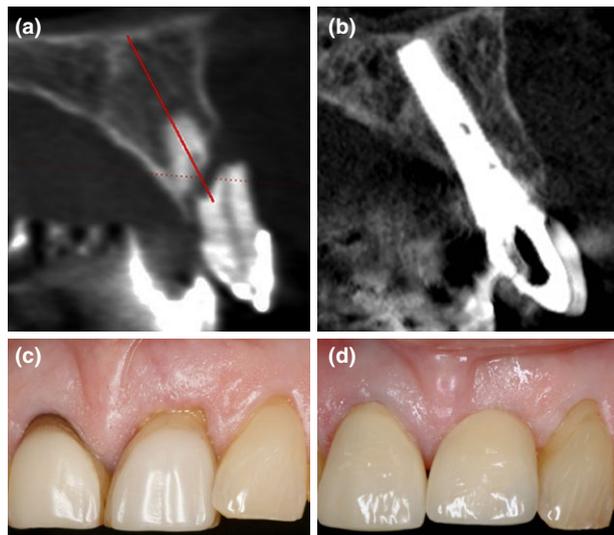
Immediate implant insertion, immediate reconstruction, and immediate provisionalization in case of recession-type defect and total loss of the facial bone wall. (a) The CB-CT at pre-operative examination is showing the severe facial bone defect following a horizontal root fracture. (b) The CB-CT at 5-year follow-up visit is presenting the facial bone reconstruction to the level of the implant shoulder. (c) Initial situation of a left central incisor showing soft tissue swelling and slight recession following a horizontal root fracture (PES 11). (d) The clinical situation at 5-year follow-up following immediate implant insertion, provisionalization, and flapless reconstruction shows matured and increased facial peri-implant tissues (PES 12)
